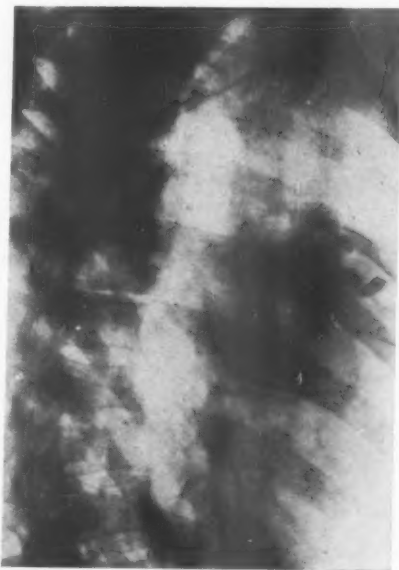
Case 1. Right oblique X-ray. Teratoma. Note teeth and bone.
